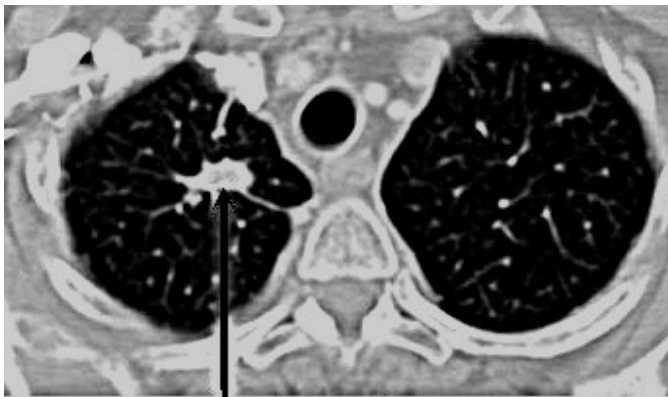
Lung Cancer detection using CT Screening Technique
